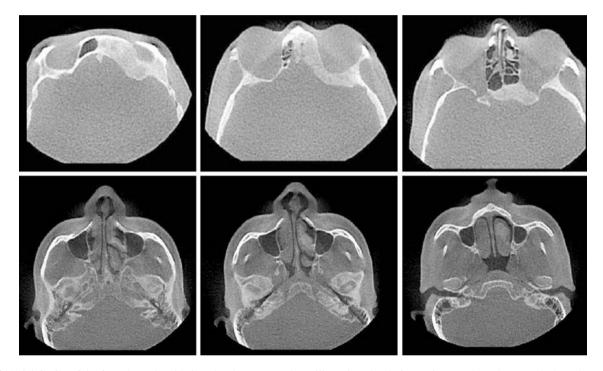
Axial CBCT of the frontal to ethmoid sinus-level (*upper*) and maxillary sinus-level (*lower*) images show the ground-glass change, with thickened appearance in the frontal, ethmoid (including the crista galli), and sphenoid bones
